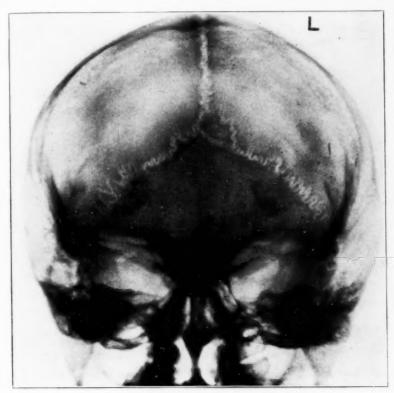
Roentgenographic appearance of calcifications.
